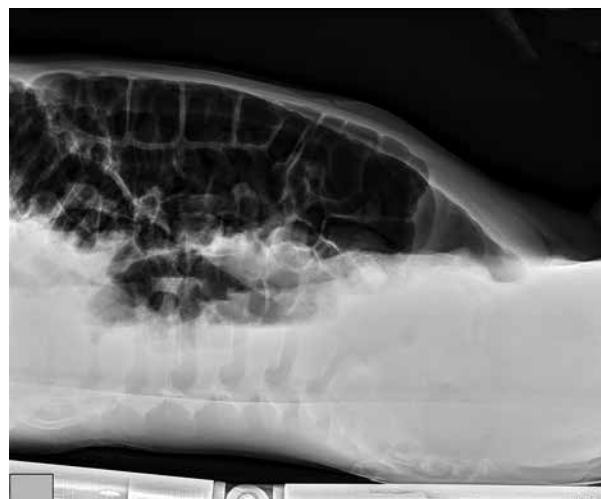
Abdominal X-ray showing distention of the colon with air-fluid levels
